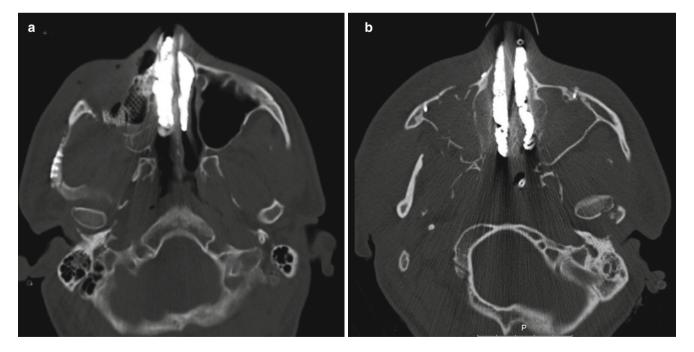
CT showing well-placed BIPP packs supporting the septum and maintaining alignment (a, b). How long these can stay in is a matter of opinion (risks of infection: see text)
